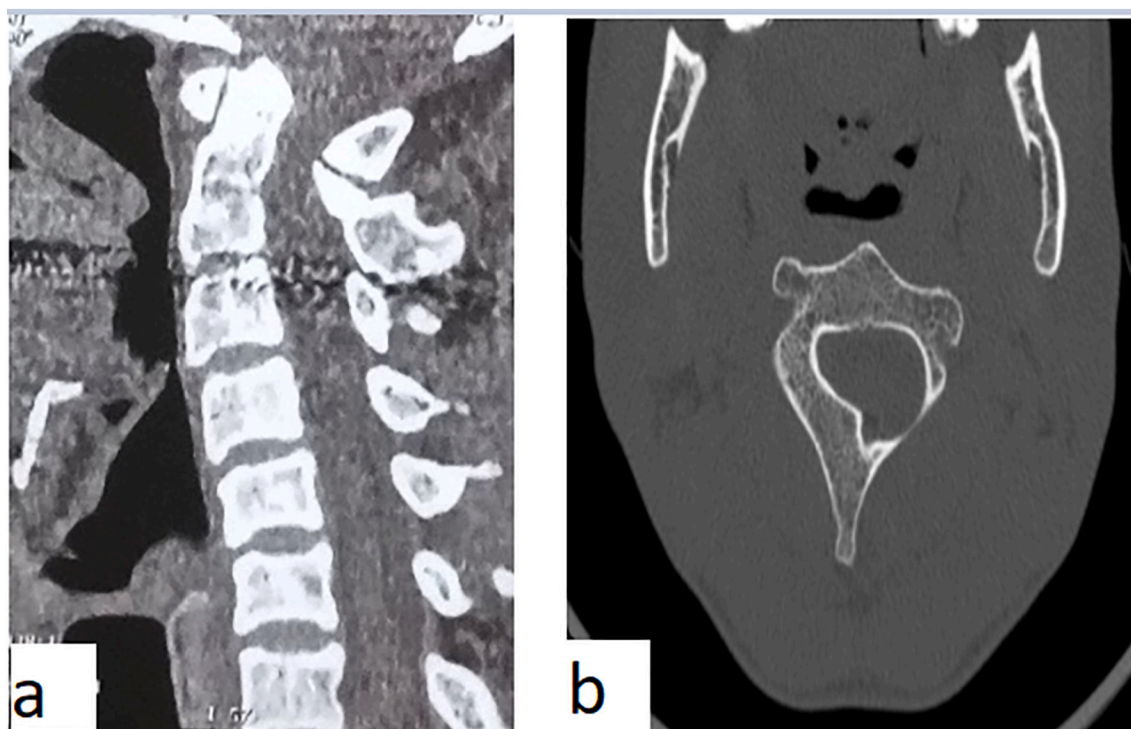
Sagittal (a) and axial (b) bone window computed tomography scan of the cervical spine showing a bony outgrowth growing anteriorly and filling the spinal canal, arising from the inner posterior arch of C2 at the right side.
